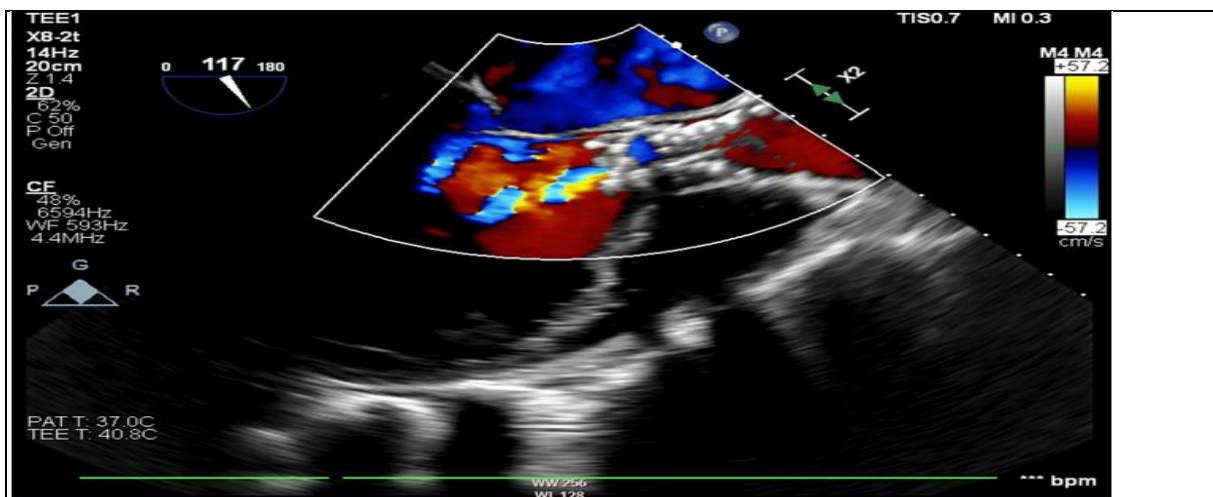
Intraprocedural transesophageal echocardiography (TEE) of the aortic valve with color doppler, mid-esophageal long axis view indicating significant prosthetic valvular regurgitation due to infolding
